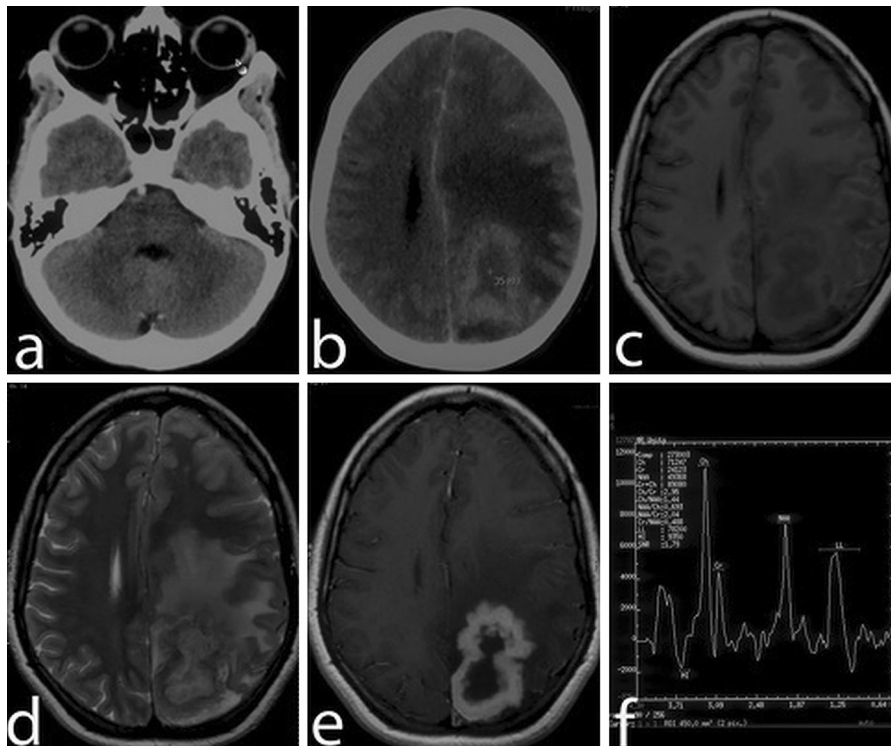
Axial CT (a) at the level of the skull base shows no evidence of paranasal sinus disease. CECT (b) reveals a nodular ring-enhancing lesion with an isodense core and perilesional edema in the left parieto-occipital region. The wall of the lesion
